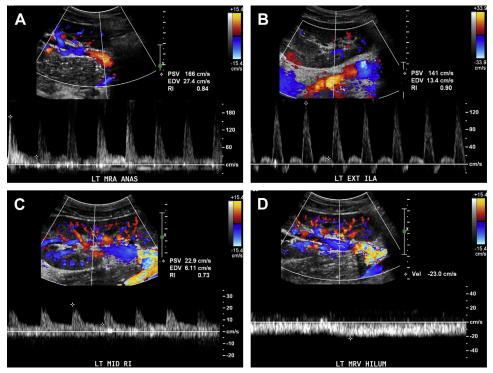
Normal appearance of renal artery anastomosis without evidence of stenosis. (*A*) Duplex Doppler of the main renal artery shows laminar flow without aliasing and normal velocity lower than 250 cm/s on spectral analysis. (*B*) PSV of the external iliac artery is included to allow calculation of renal artery/iliac artery ratio lower than 1.8. (*C*) Indirect evaluation of the segmental artery shows no abnormal resistance or delayed systolic acceleration. Note that the early systolic peaks in this patient may not always be present even in a normal transplant. (*D*) Main renal vein has normal phasic flow.
